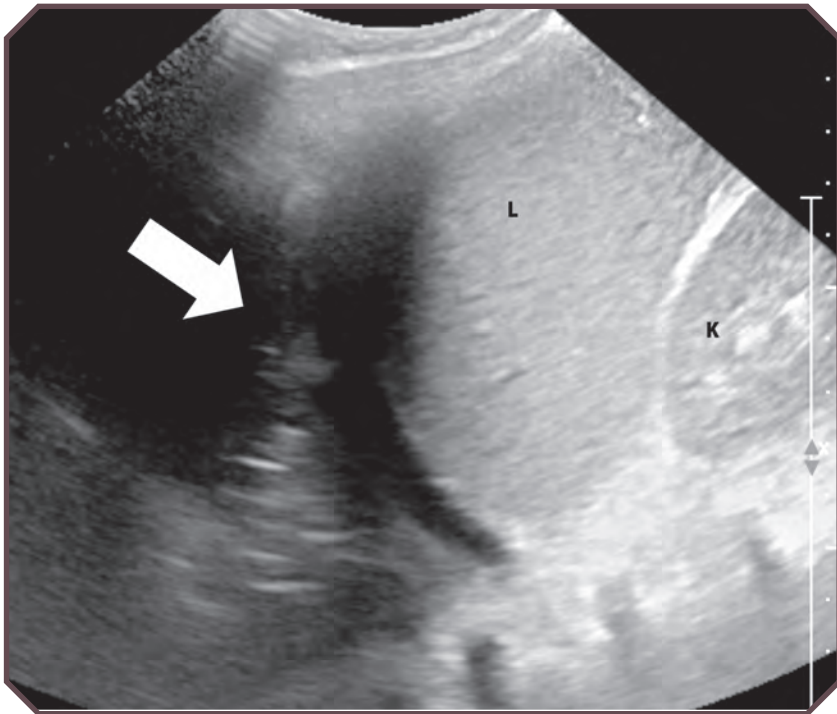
Pleural effusion. Sagittal ultrasonographic image demonstrates a left pleural effusion (arrow). Normal liver (L) and right kidney (K) are partially visualized.
